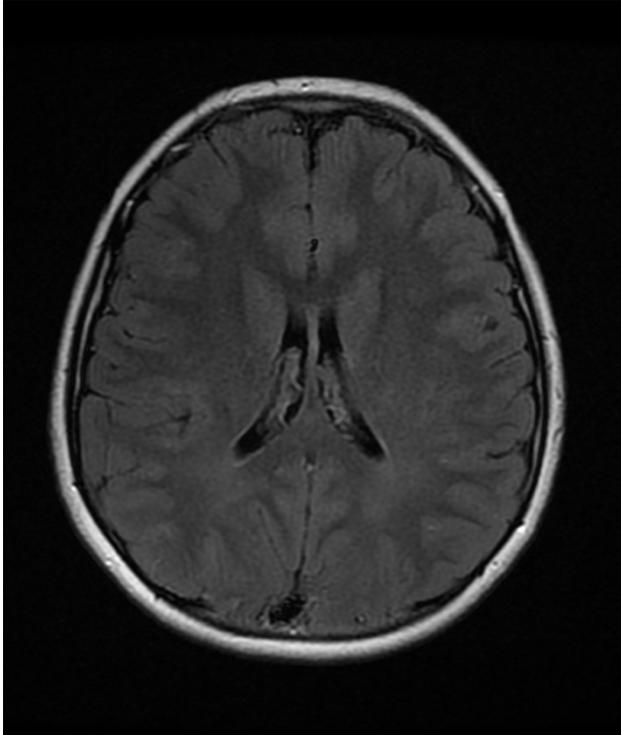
Follow up MRI of the brain demonstrates resolution of lesions in parietal white matter and corpus callosum on the corresponding axial T2 FLAIR image.
